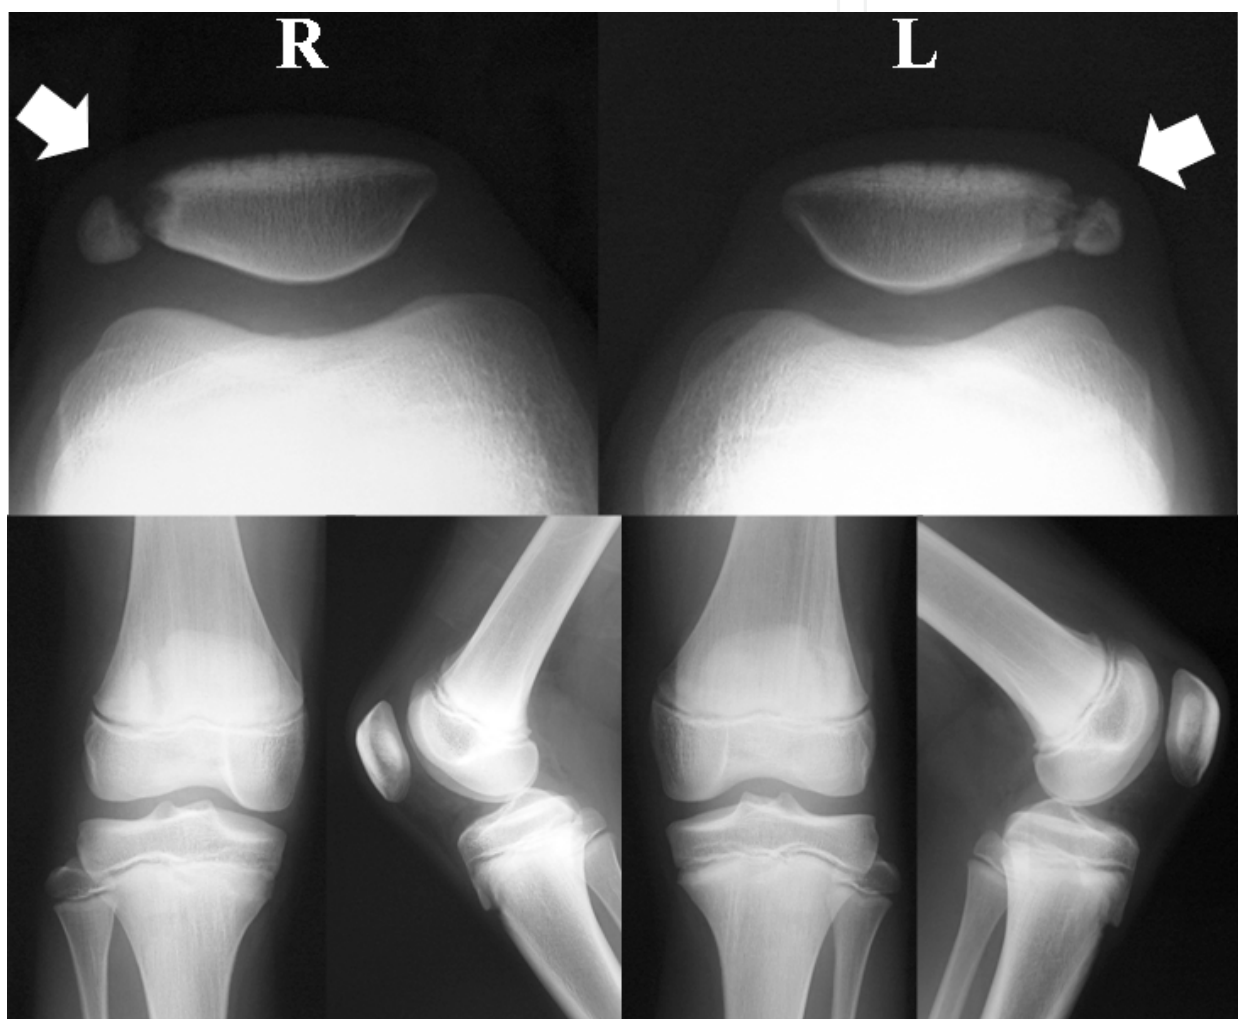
Plain radiography in Case 1. Left figures show the right knee, right figures show the left knee.
